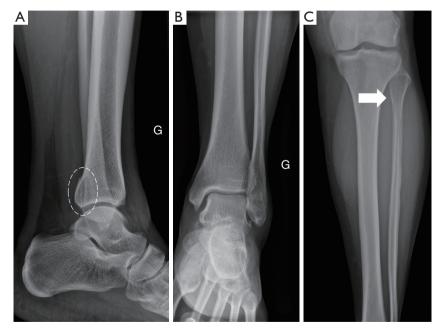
Left (G) ankle radiographs of case 2 at day 1. (A) Lateral left ankle radiograph showing a posterior malleolus fracture (white circle in dashed line). (B) AP left ankle radiograph showing a mortise in an anatomical position and the absence of tibio-fibular diastasis. (C) AP left leg radiograph showing a proximal fibula fracture (white arrow). AP, anterior-posterior.
